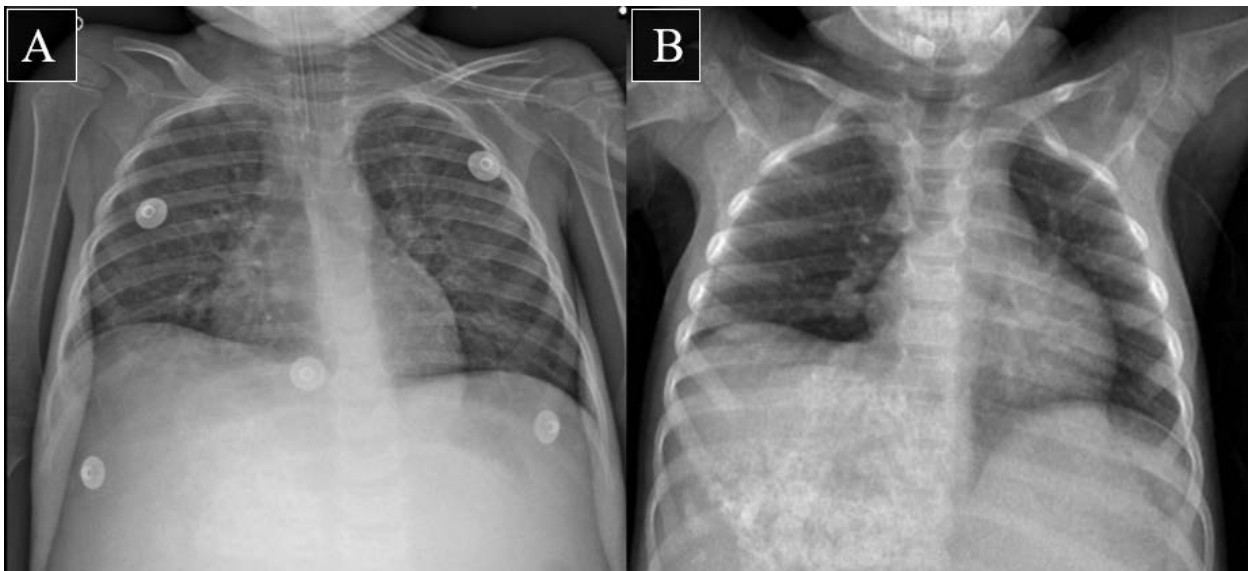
Chest radiograph during HFOV use (A) and chest radiograph on May 16, 2023 (B)
